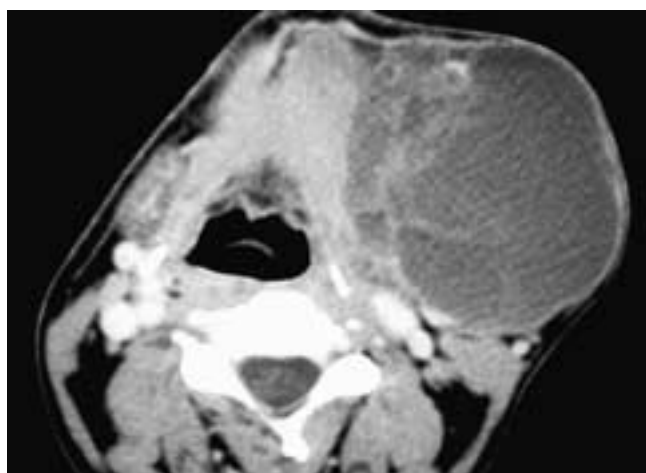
Axial CT scan shows a large cystic mass with slightly unsharp margins in the left submandibular gland. This patient had a cystic lymphangioma.
